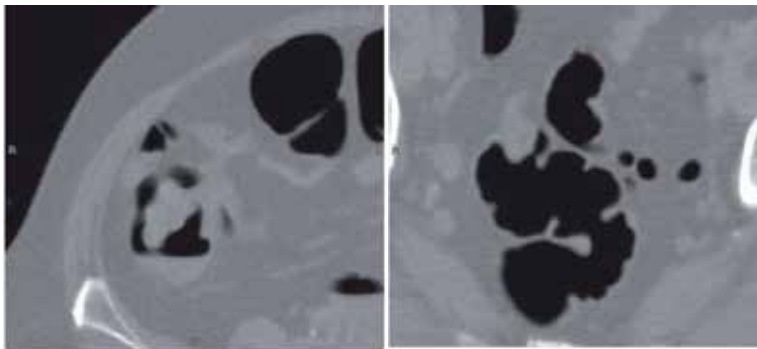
Virtual colonoscopy – a view of pediculated polypus and a small carcinoma - CT images.
